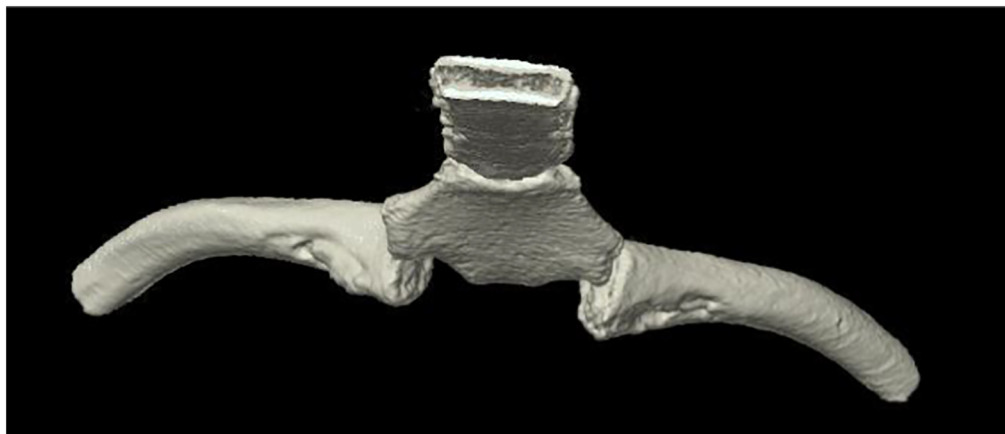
Post-reduction CT scan.
